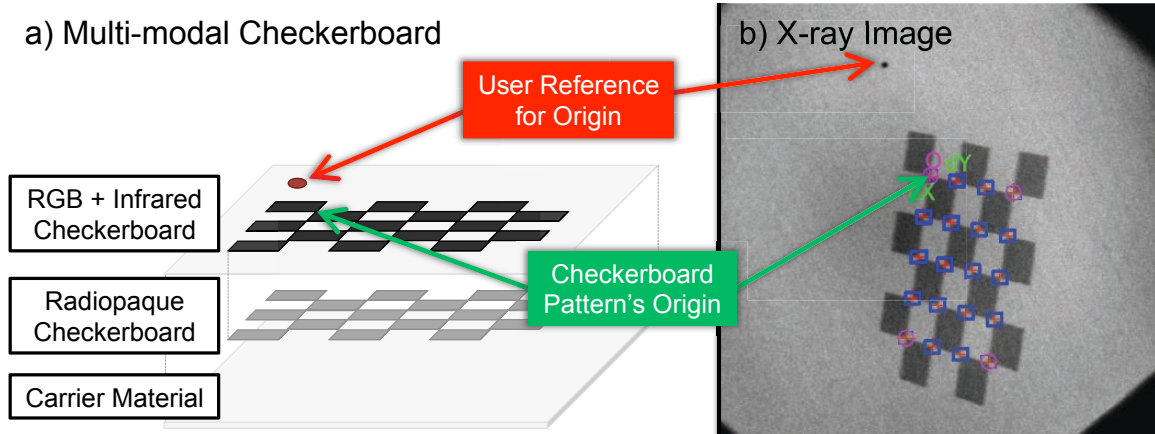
Checkerboard is designed to be fully visible in RGB, depth, and X-ray images.
